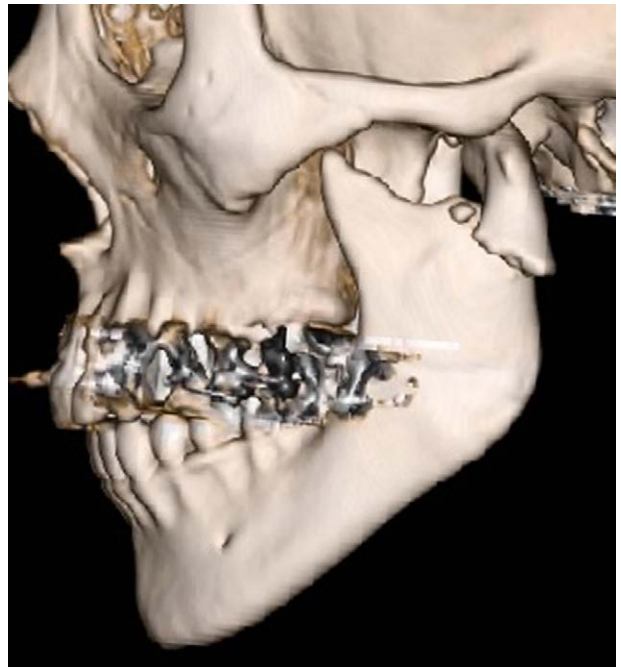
Three-dimensional computed tomography findings in the left mandibular condylar base fracture with lateral displacement.
